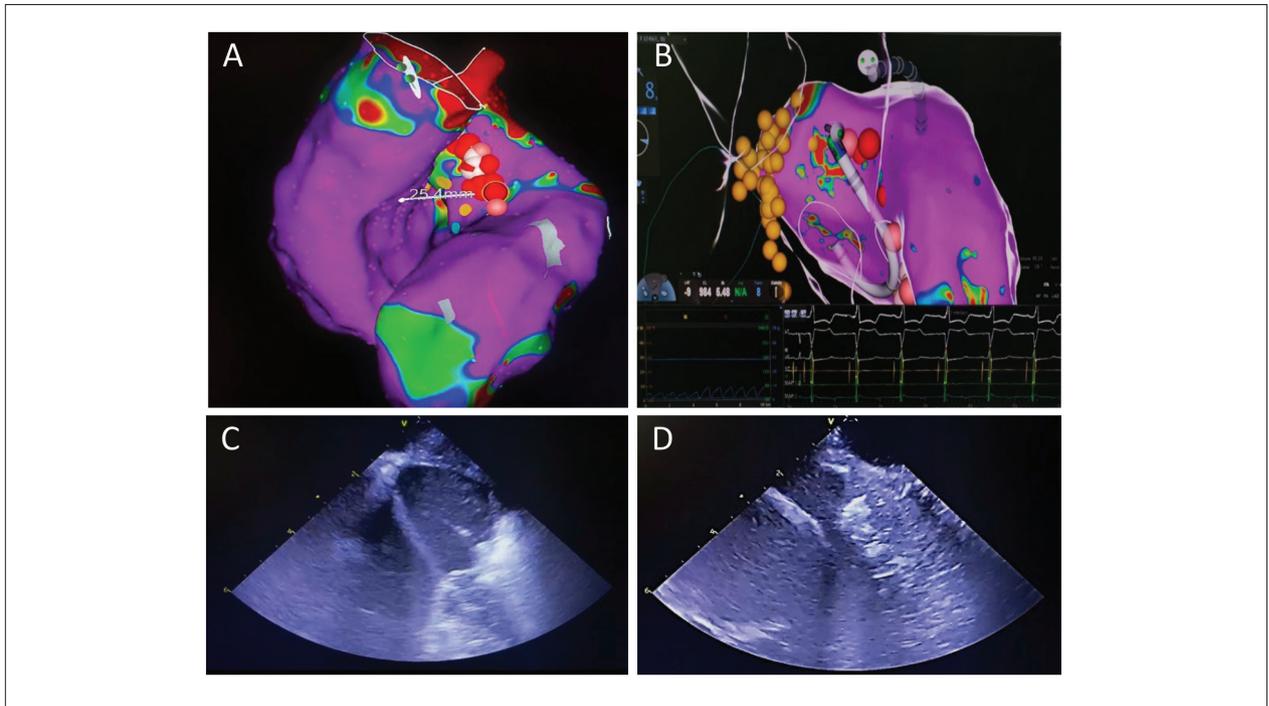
Carto 3-guided electroanatomic maps of the right and left ventricle. This picture shows the point with the largest septal thickness (25 mm). The points in red represent the region where the radiofrequency was applied. B) Beginning of the application of radiofrequency. The yellow points represent the areas to be avoided in which the conduction system was identified. C) Hyperechogenicity of the septal region, evaluated continually using the intracardiac echocardiogram during the application of radiofrequency. It is possible to identify the catheter in the strap resting on the septal region. D) At the end of the procedure, an intense edema is observed in the septal region, associated with hyperechogenicity near the left ventricle outflow tract.
